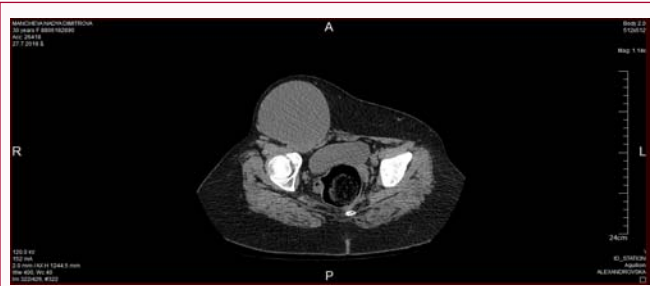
CT scan confirmed ovarian cyst into the inguinal canal.
